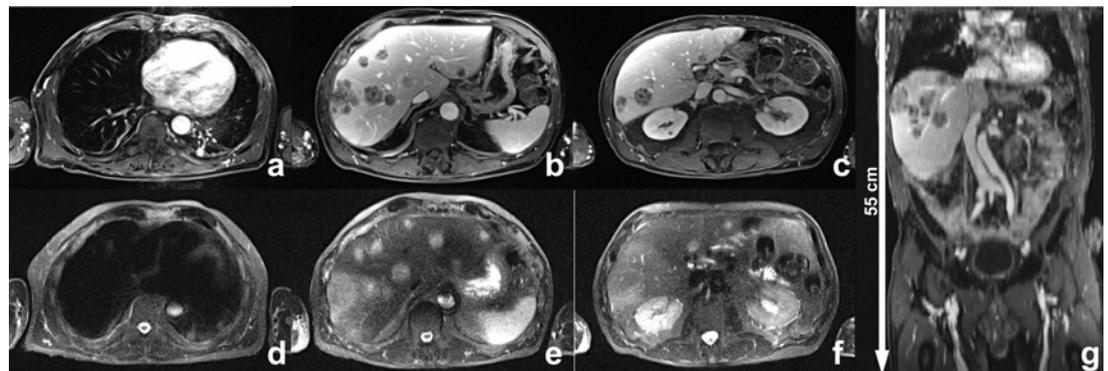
Example images from one of the examined patients. Left: original axial slices used for diagnosis showing multiple metastases in the liver. (a-c): CE T1-weighted GRE with fat sat. (d-f) STIR-TSE. Right: reformatted coronal whole FOV<sub>z</sub> overview from Seq. 3 (g). The arrow indicates the direction of data acquisition.
